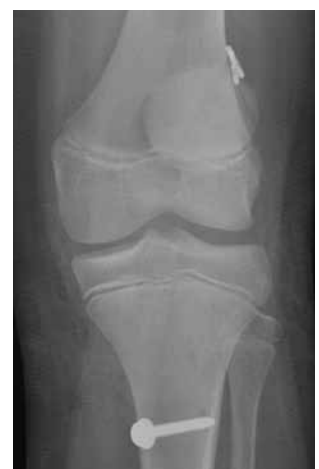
Postoperative anteroposterior radiograph of patient who underwent complete transphyseal anterior cruciate ligament reconstruction.
